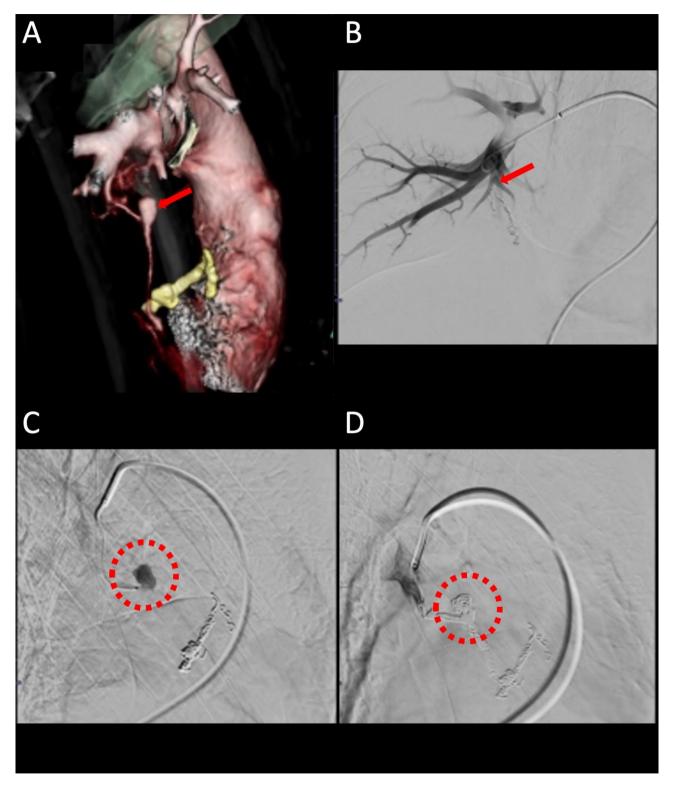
CT detection of a second pulmonary artery pseudoaneurysm and fluoroscopic images of coil embolization. A Three-dimensional CT to detect pseudoaneurysm in A8 branch (red arrow). B Angiography to identify the responsible vessel (red arrow). C Pseudoaneurysm delineated by red dashed circle. D Coil embolization of the pseudoaneurysm (red dashed circle)
